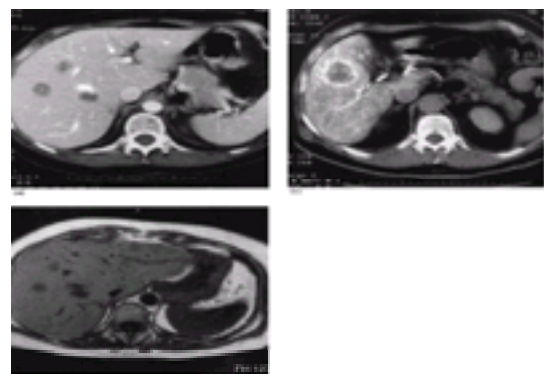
(a) Biphase spiral CT of the liver showing colorectal metastases. (b) Angiographically assisted CT of the liver showing a colorectal metastasis. (c) MRI of the liver showing colorectal metastases.
